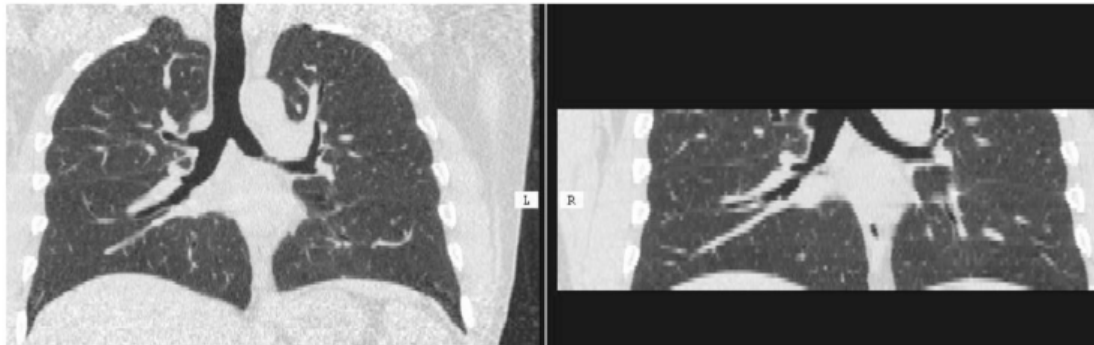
Lung windows from full chest CT vs cardiac CT exams side by side comparison (22).
